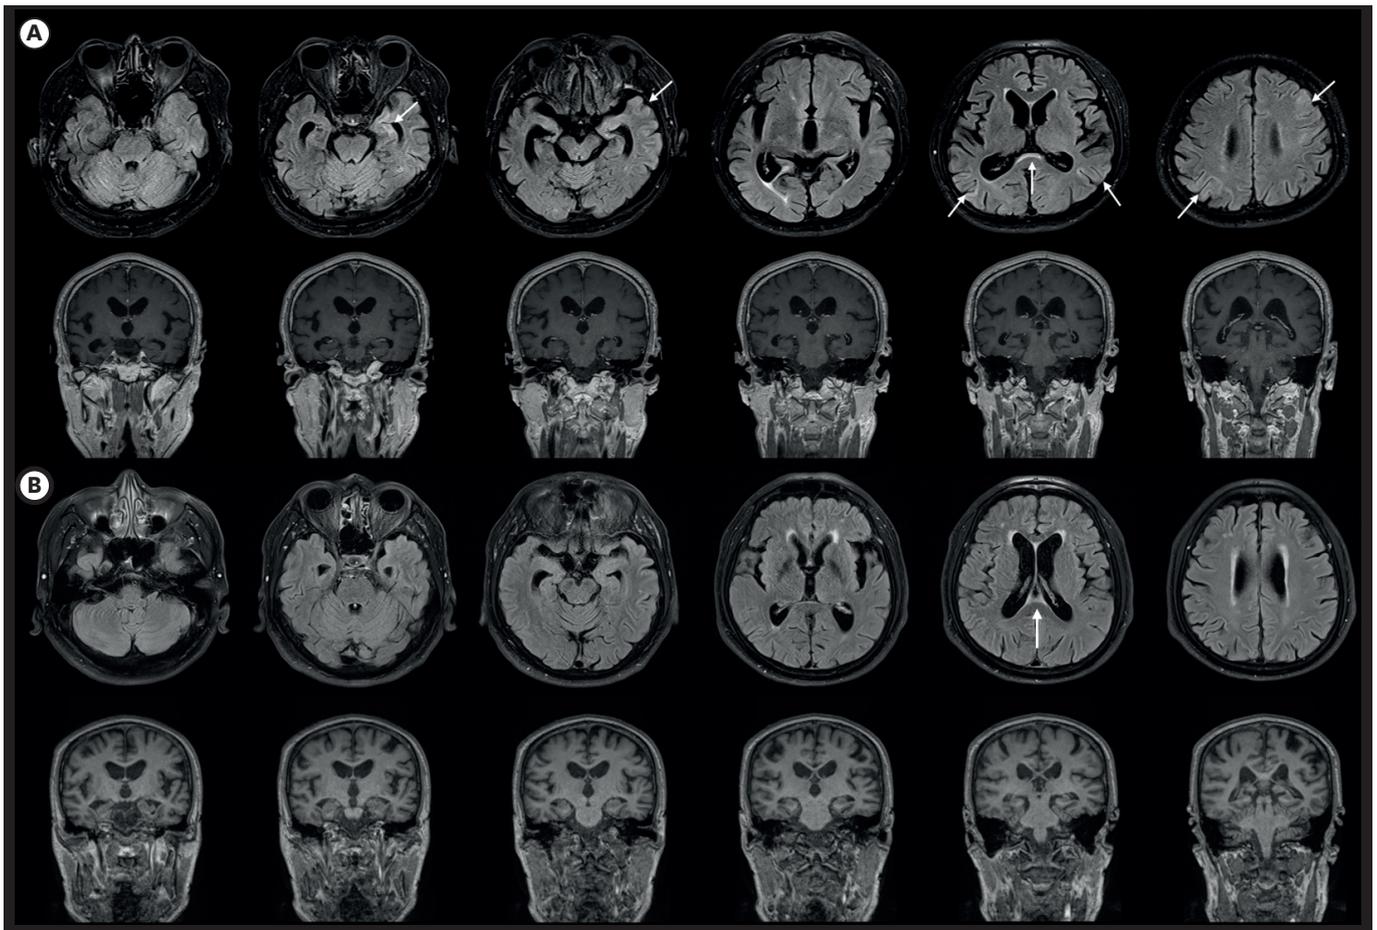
Patients' brain MRI. (A) Case 1: MRI shows diffuse cortical atrophy and multifocal hyperintensities in the splenium, left temporal, both the parietal and frontal cortices; (B) Case 2: MRI shows diffuse cortical atrophy and hyperintensity in the splenium. MRI: magnetic resonance imaging.
